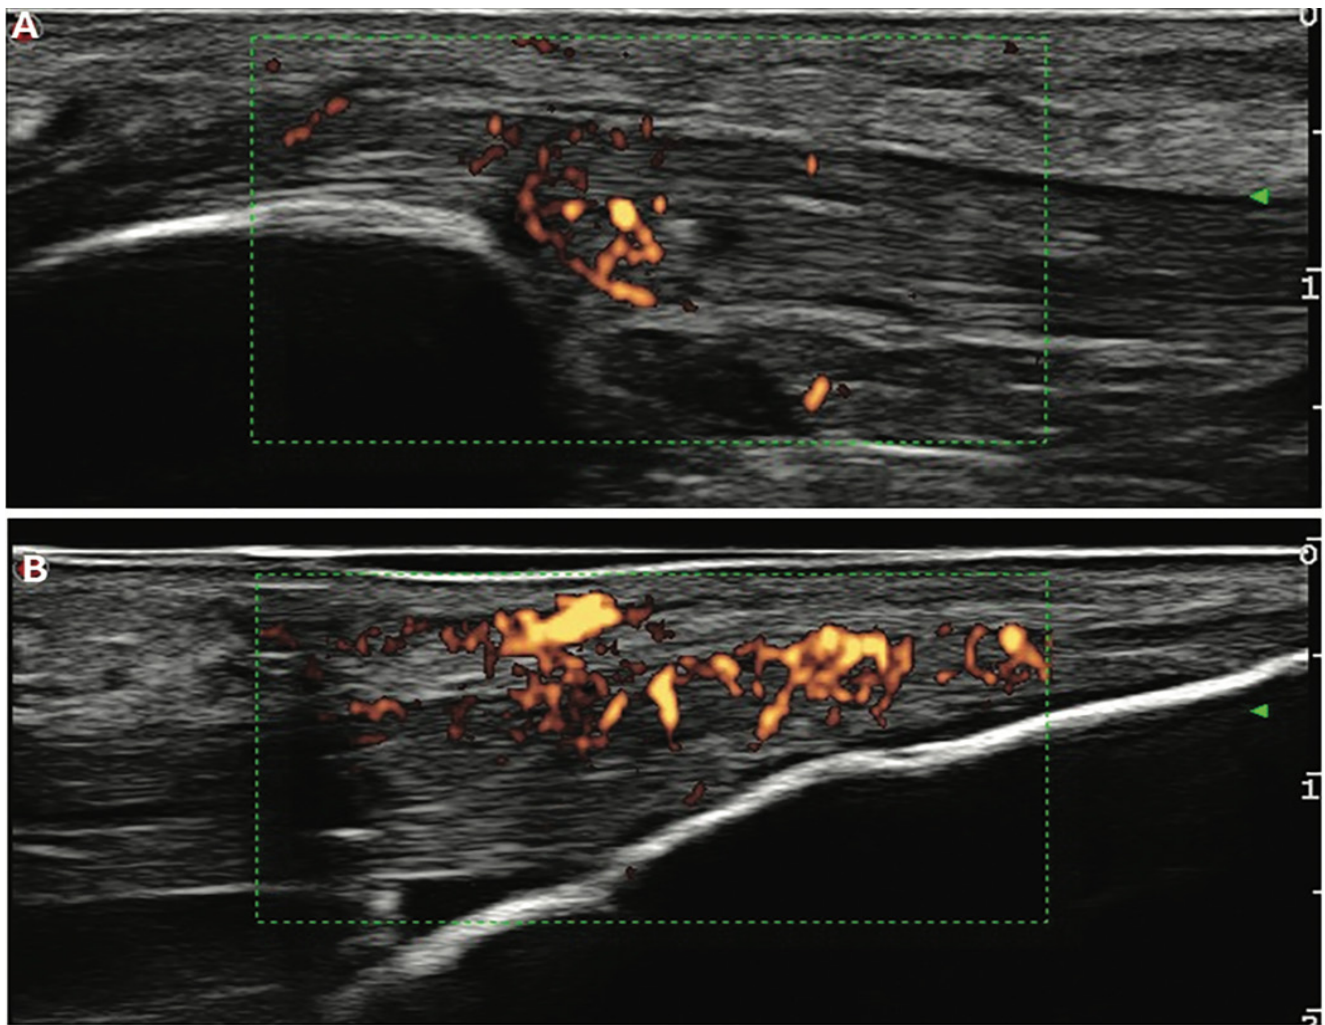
Power-Doppler ultrasonography of proximal and distal patellar entheses in a patient with psoriasis.
